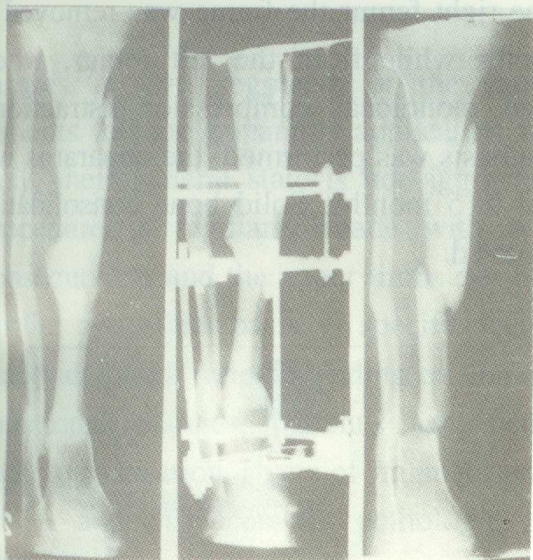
X-rays of patient M.: left - before treatment; middle - during osteosynthesis, right - 2 years after treatment
